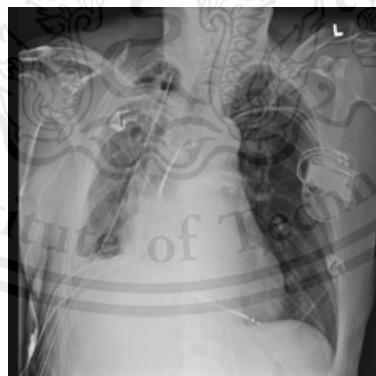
Example of Pneumothorax chest X-Ray image (Wang, Yifan Peng, Le Lu, Zhiyong Lu, & Ronald M. Summers, 2018)
